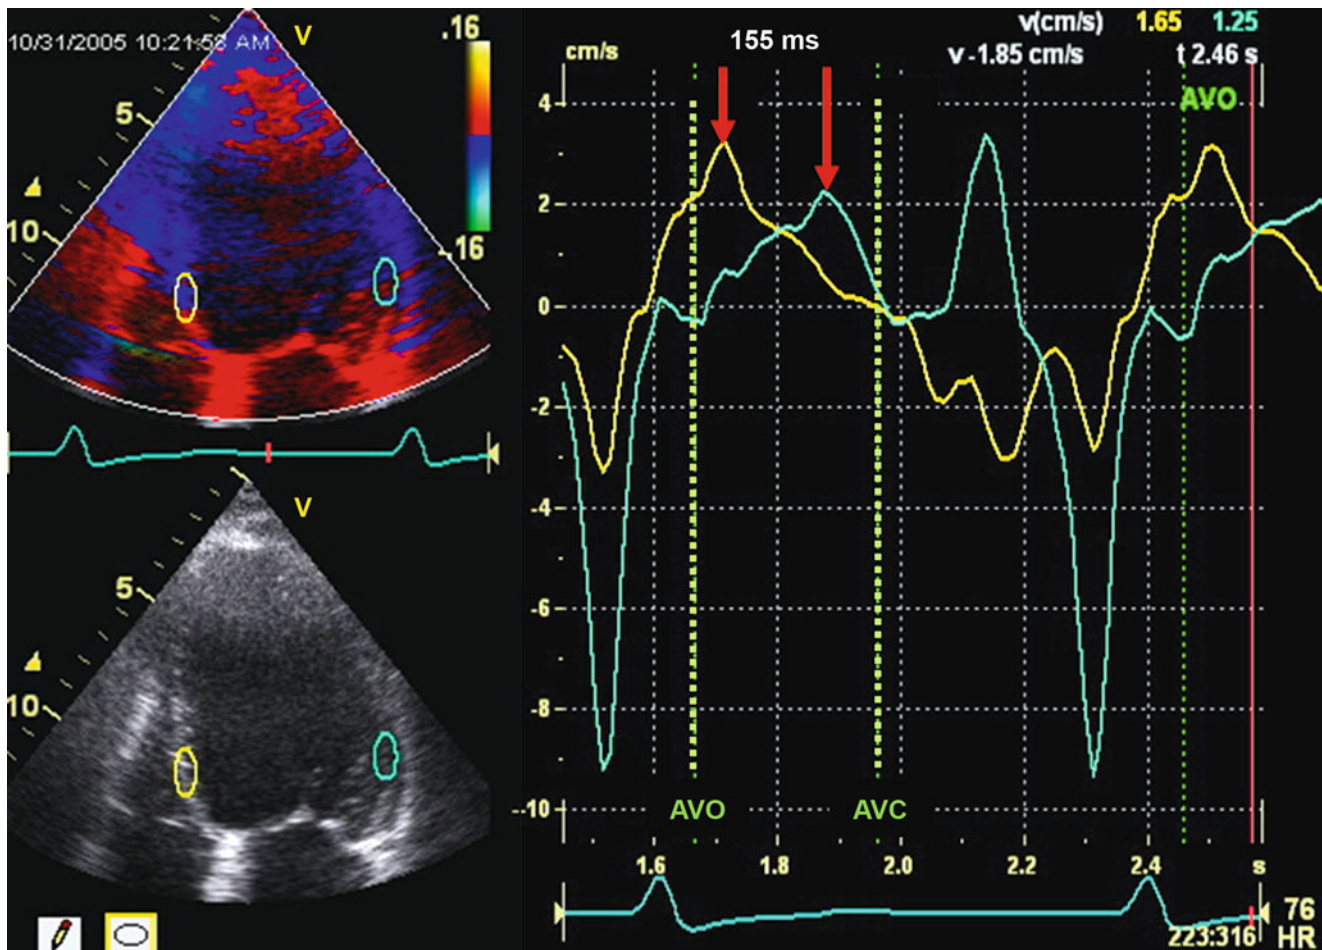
An example determination of the tissue Doppler two-site opposing wall delay from the 4-chamber view from a patient with left bundle branch block. The opposing wall delay is assessed as the time
